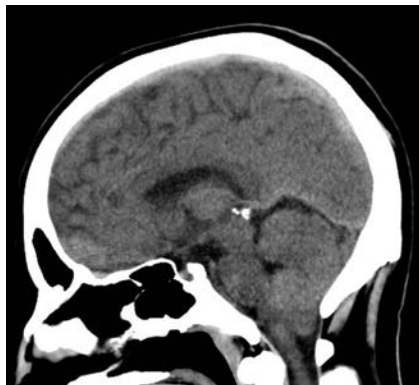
Sagittal CT head.
